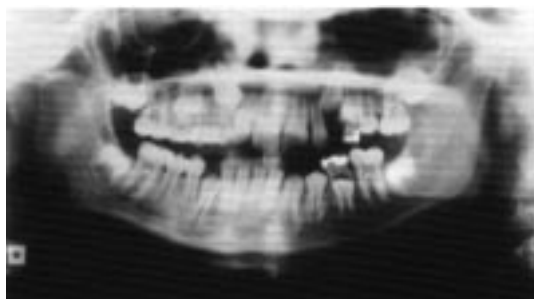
Orthopantomogram showing atypical condyles, especially the right.
